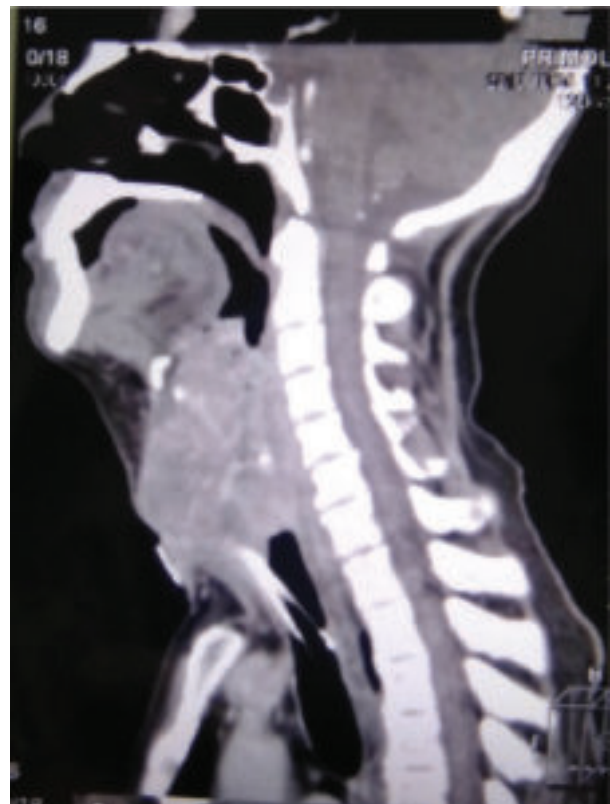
Sagittal post-contrast CT scan of neck showing large laryngeal growth (Ca-larynx).
